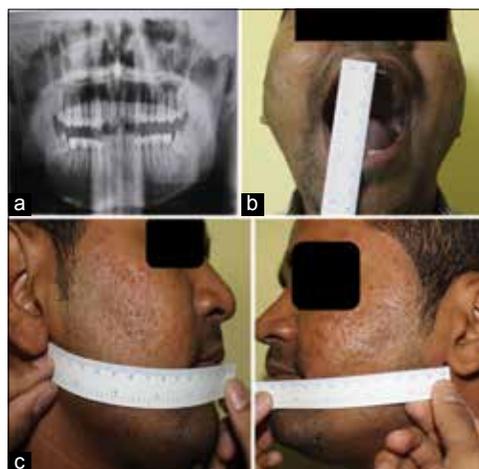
Pre operative photograph. (a) Orthopantomograph. (b) Mouth opening. (c) Swelling measurement
